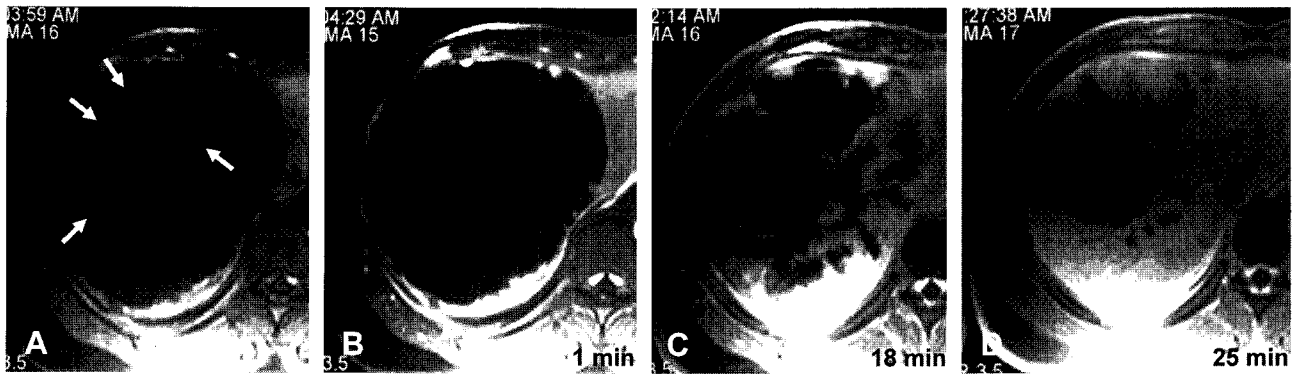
(A) T1-weighted MR image showed a huge, low signal intensity mass in the right hepatic lobe with multiple areas of high signal intensity (arrows) suggesting clot formation within the mass. (B-D) Dynamic contrast-enhanced T1-weighted MR images demonstrated a peripheral enhancement followed by progressive central fill-in of the mass; the typical enhancement pattern of hemangioma. Laboratory findings revealed; WBC 9,800/ μ l, hemoglobin 9.6 g/dl, and platelet 75,000/ μ l. His reticulocyte count was 8%. A peripheral blood smear revealed polychromasia with numerous fragmented red blood cells. His prothrombin time (1.6 INR) and partial thromboplastin time (40.8 sec) were prolonged. His plasma fibrinogen (138 mg/dl) and antithrombin III (25%) levels were low, and total bilirubin (2.2 mg/dl), lactate dehydrogenase (662 IU/L), and fibrin/fibrinogen degradation product (>100 μ g/ml) levels were elevated. The patient was diagnosed as having KMS composed of a giant hepatic hemangioma with consumptive coagulopathy, thrombocytopenia, and microangiopathic hemolytic anemia.^{1,2} This syndrome may also be associated with occult hemangiomas located at various sites, such as, the liver or spleen, head or neck, extremities, and trunk, and may lead to life-threatening bleeding. Tc-99m RBC scintigraphy and SPECT using total body blood pool imaging study were also performed.
